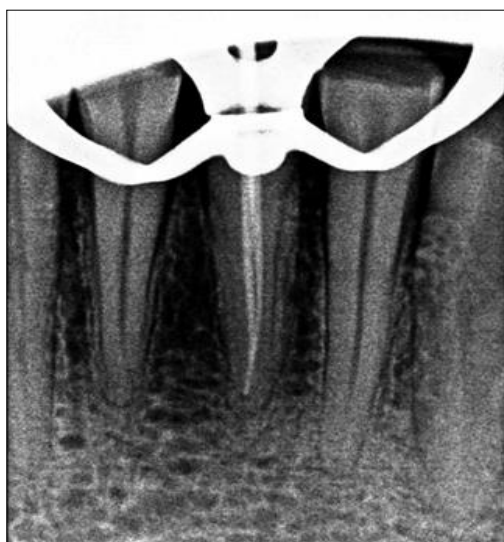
Preoperative intraoral periapical radiograph showing suggestive evidence of an additional canal
